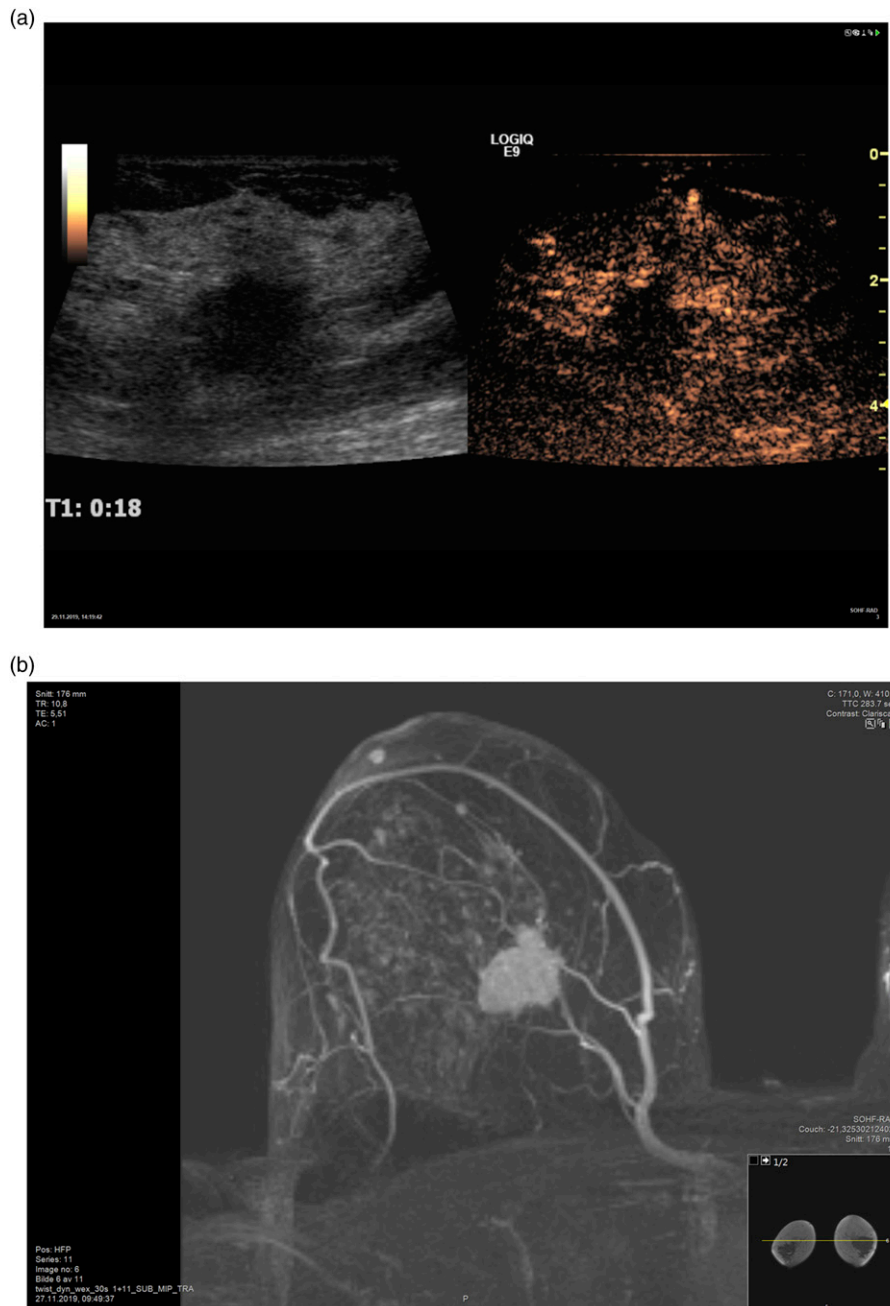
Hypoenhanced mass with poorly defined margins and hyperenhanced surrounding tissue (a). Corresponding magnetic resonance imaging (b).
